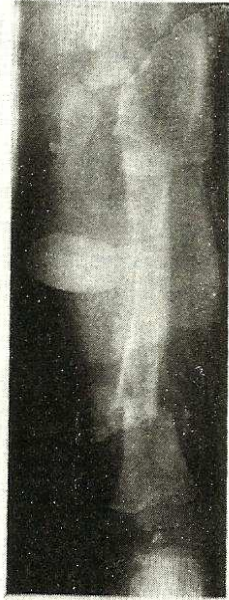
Radiograph of a fracture of the distal third of the left femur in a patient with Hb S and salmonella osteomyelitis. Note the extensive diaphysal infarction, longitudinal intracortical fissures ("bone-in-bone" appearance) and excessive involucrum formation.
